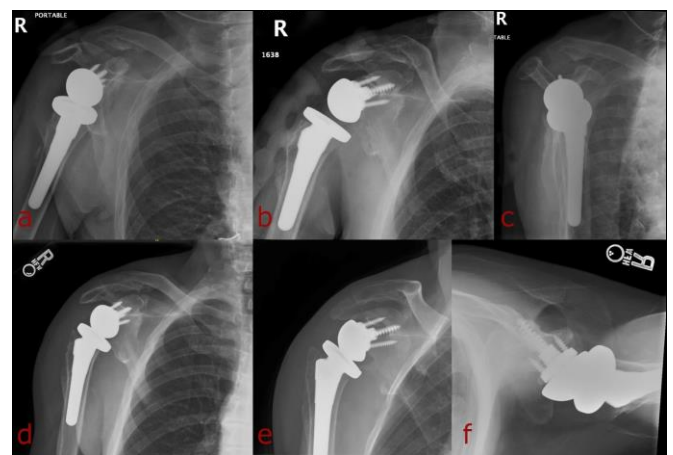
Right shoulder radiographs taken immediately (images a-c) and two weeks (images d-f) status post reverse total shoulder arthroplasty. Views: (a,d) anterior-posterior [AP], (b,e) Grashey, (c) Scapular-Y, (f) Axillary.
